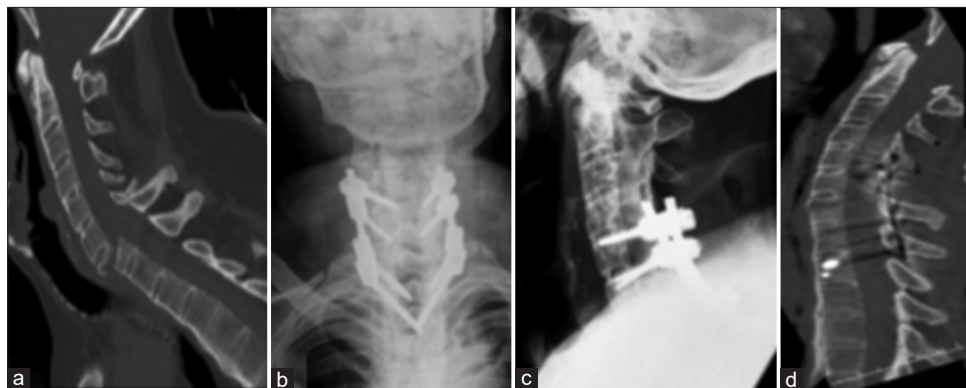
Male, 50-year-old, ankylosing spondylitis. Fall from height. AO Spine C6-C7: C (C7 B3; F4 b1; N0; M3). Frankel E. CT showing a fracture with translation at the level of C7 (a), We opted for reduction and posterior fixation with C5-T2 pedicle fixation, including two levels above and below the lesion (b and c), Control tomography demonstrates adequate reduction (d). CT: Computed tomography
